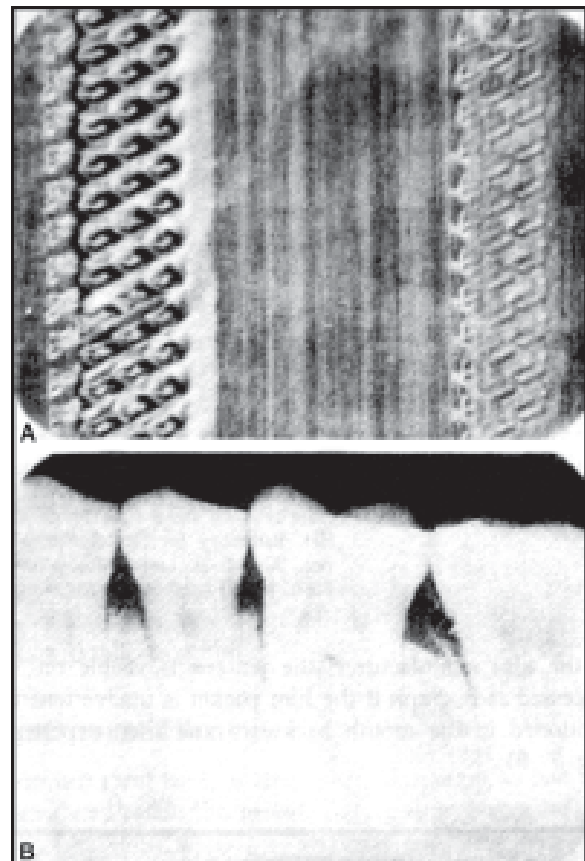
A. The lead foil insert in the packet has a raised diamond pattern across both ends. B. Radiograph showing the raised diamond pattern from the lead backing when the film is positioned backwards
